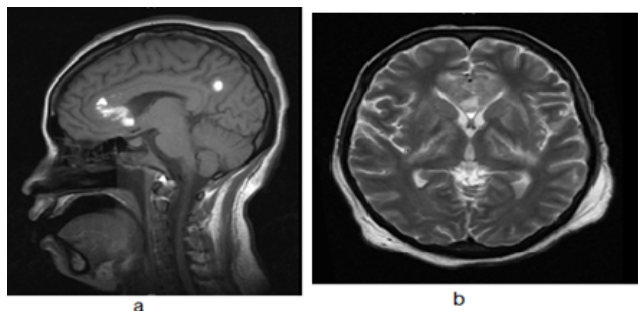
(a) Sagittal view of T1 weighted MRI showing foci of haemorrhage at genu corpus callosum and left parasagittal lobe (b) T2/FLAIR no focal white matter hyperintensities apart from perilesional oedema secondary to haemorrhage.
